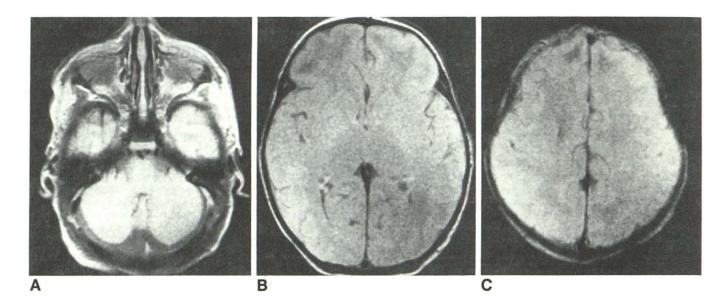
Case 2. A-C, Initial (8 days postnatal) axial T1-weighted MR images (600/20) show that ventricles and sulci are small, compatible with normal parenchymal volume.
